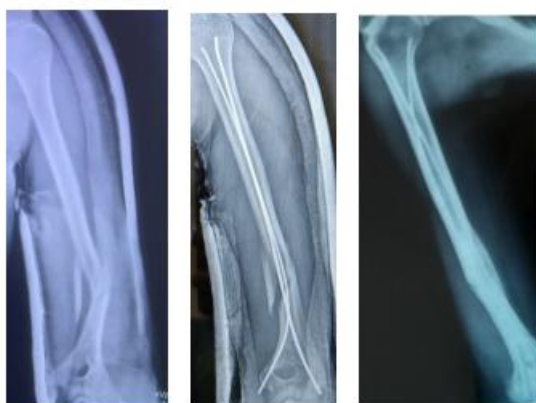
Serial radiograph of the humerus: Pre-operative AP view x-ray, Immediate post operative AP view x-ray, 6 months follow up AP view x-ray.
